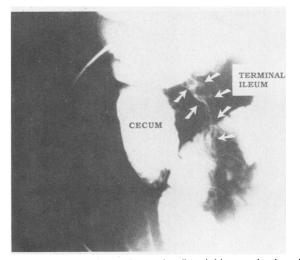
A barium-enhanced radiographic examination of the intestine reveals cuffing of the terminal ileum (arrows) characteristic of Crohn's disease.
